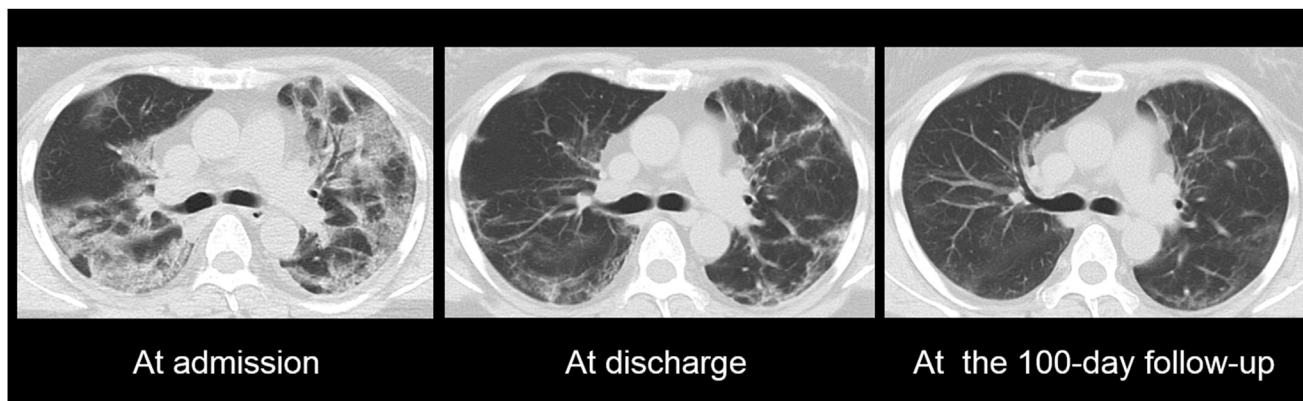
Representative computed tomography images taken at admission, discharge and 100 days after symptom onset.
